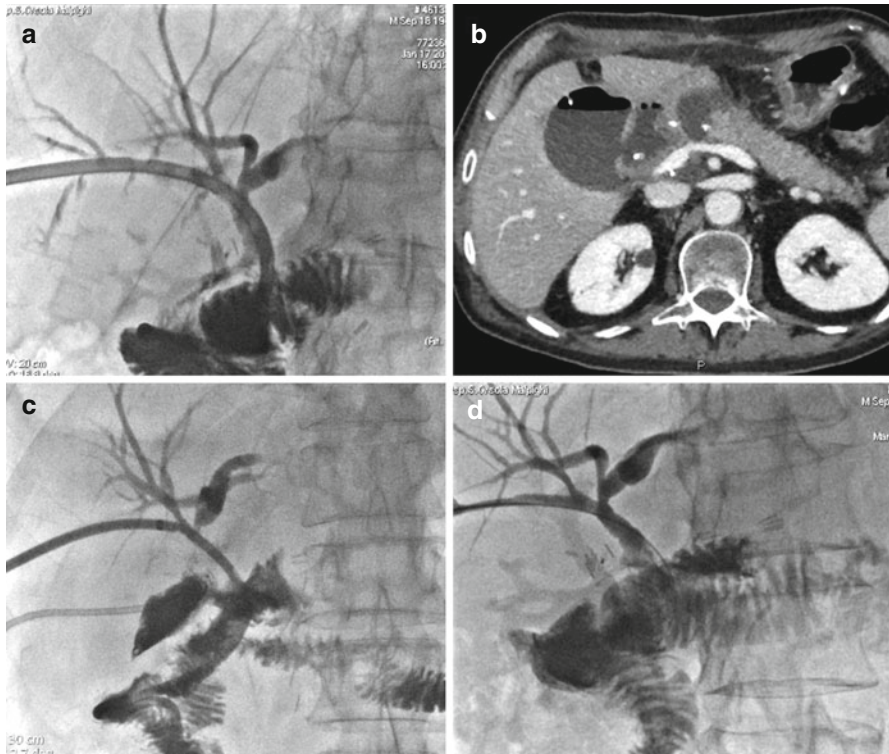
(a) Cholangiogram shows a fistula at the site of the biliodigestive anastomosis, with an associated collection (biloma) as demonstrated on CT scan (b). The cholangiographic follow-up, performed 20 days after biliary drainage insertion and external drainage positioned under CT guidance into the biloma, shows reduction of the leakage (c). The cholangiographic follow-up at 40 days, after external drainage removal, shows resolution of the fistula, and therefore the biliary drainage was removed (d)
